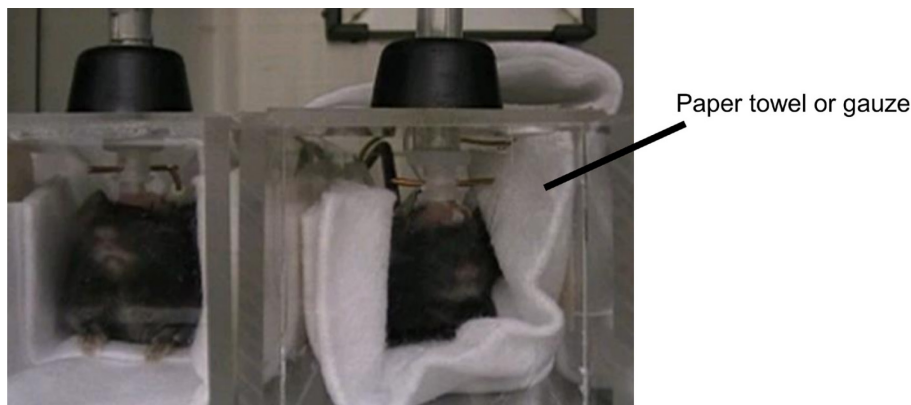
Acclimation training with pseudo-MRI head positioner
